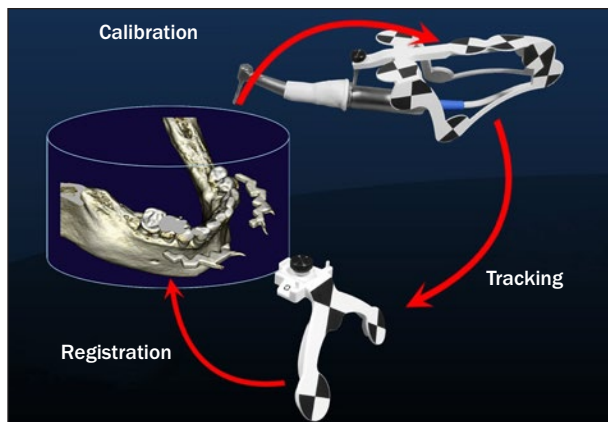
The three coordinate mapping steps that, when chained together, map the drill tip to the planning CBCT image volume.
